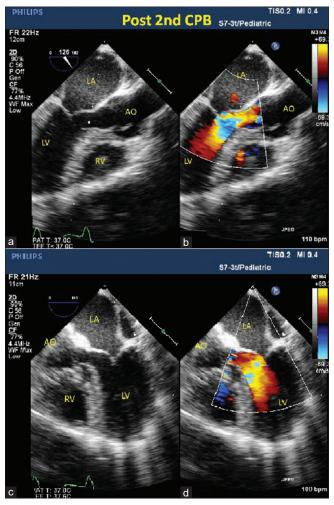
TEE evaluation after septal myectomy. (a and b): ME aortic valve long-axis view showing a widened left ventricular outflow tract and a color doppler showing non-turbulent flow across left ventricular outflow tract and no mitral regurgitation. (c and d): ME 5-chamber view showing a two dimensional image after septal myectomy, and a color doppler image showing a non-turbulent flow across left ventricular outflow tract with no mitral regurgitation (LA: left atrium; LV: left ventricle; RV: right ventricle; AO: aorta)
